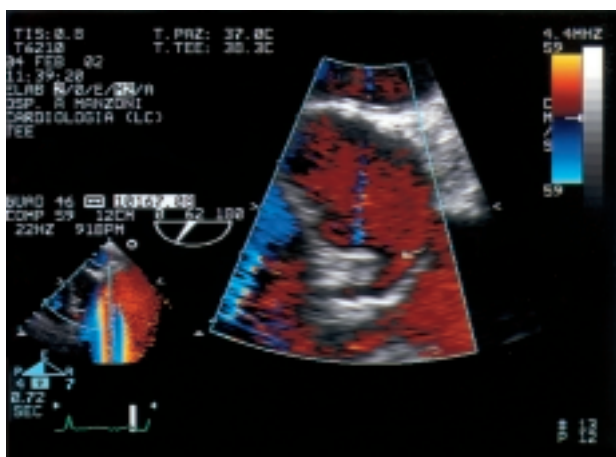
Modified transesophageal color Doppler short-axis view of the aortic root.
